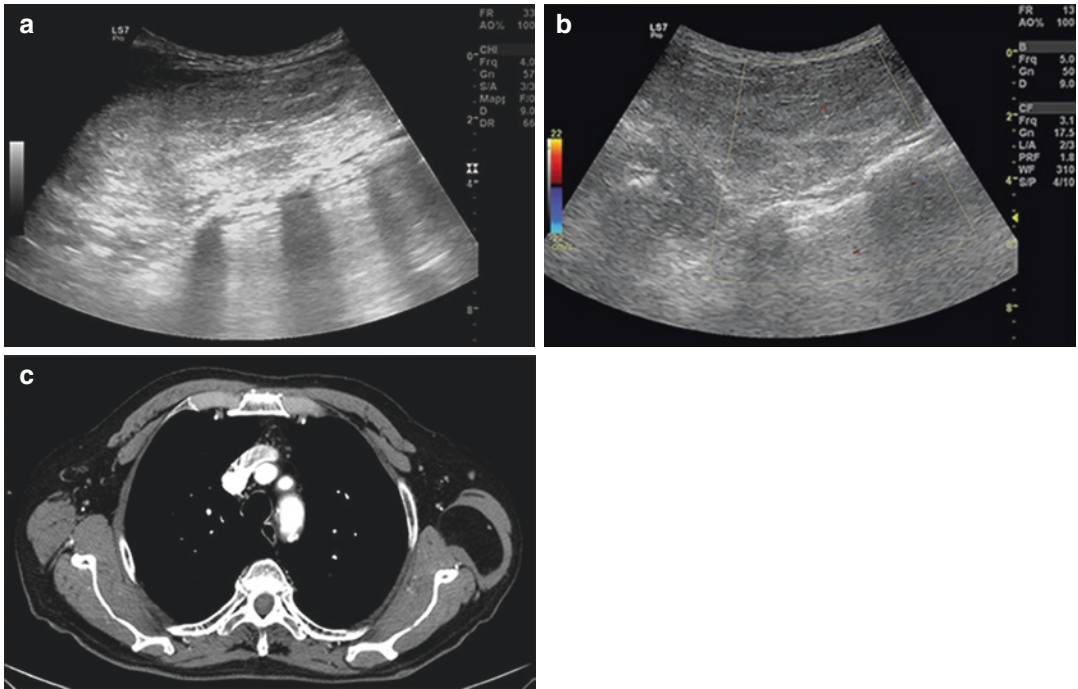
Ultrasound (a, b) and CT (c) of coarse lipoma in the context of the left latissimus dorsi muscle. The colour-Doppler (b) showed no vascular signals. The CT confirmed uniform adipose density of the lesion
